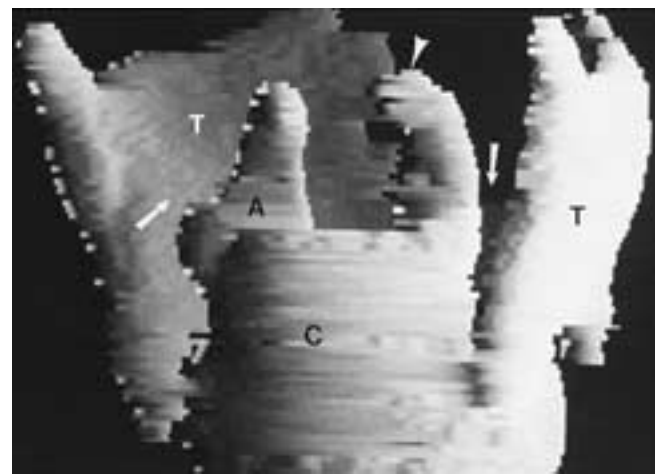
Computer reconstruction of the larynx, from axial CT scans, is viewed from posteriorly and slightly to the right. The arytenoid (*A*) is perched on the lamina of the cricoid cartilage (*C*). Thyroid cartilage is represented by the letter *T*. Arrows show the thyroarytenoid gap representing the position of the apex of the pyriform sinus. The arrowhead shows the corniculate cartilage.
